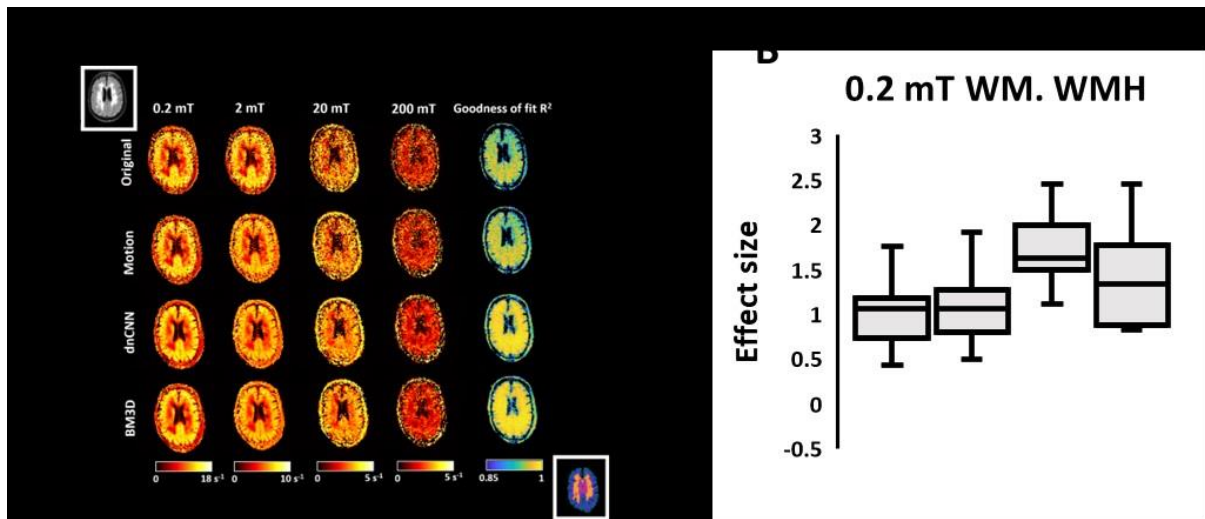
R1 mapping improvement. A) Rows 1-4 corresponds to four preprocessing methods. Motion correction was applied before each denoising approach. Columns 1-4 contain R1 maps generated at each magnetic field strength. The 3T MRI FLAIR image and tissue label map are shown. SVD WMH is orange on the tissue label. B) Box whisker plot for cohort effect size.
